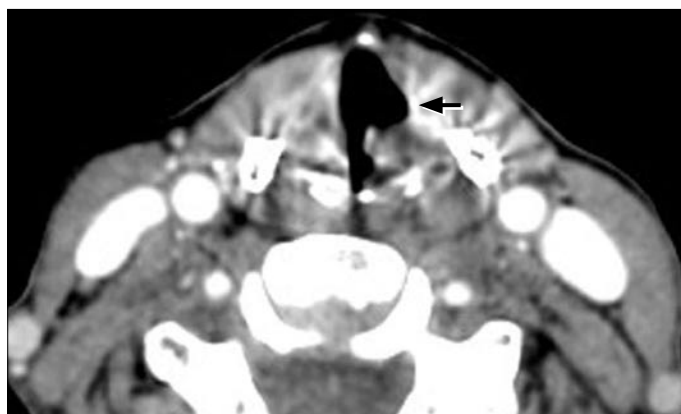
Axial CT image through the larynx reveals a dilated left laryngeal ventricle (arrow).
